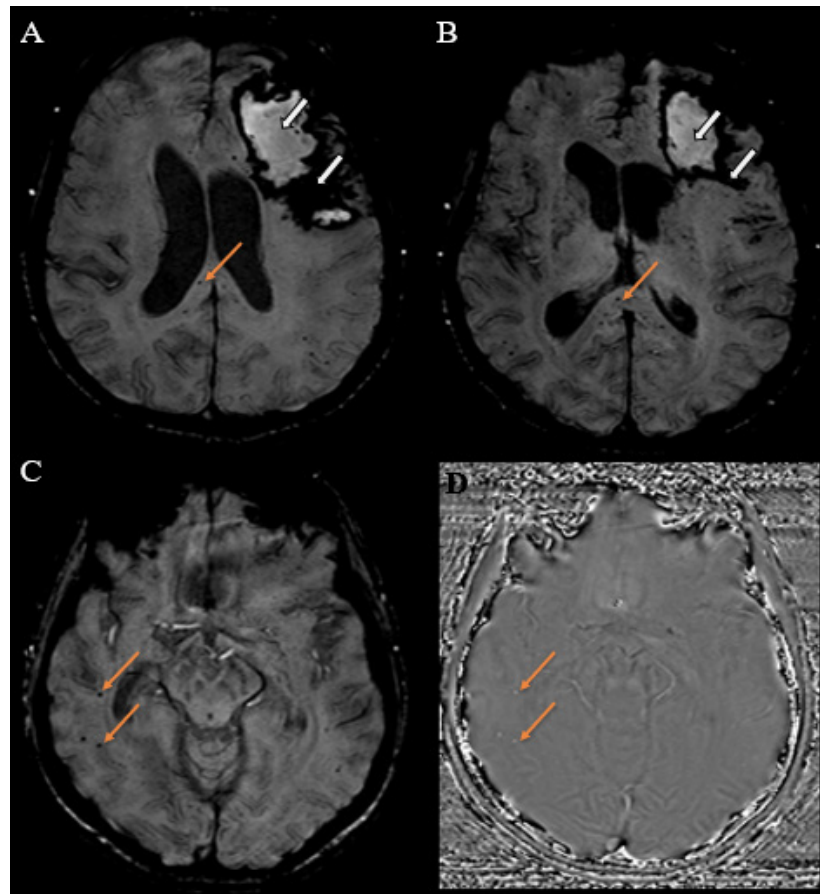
MRI SWI (a, b, c) and phase-map image (d) demonstrate surgical changes and blood degradation products in left frontal lobe. Note multiple subcortical and deep microbleeds in both cerebral hemispheres and corpus callosum, what may be associated with thrombotic microangiopathy.
